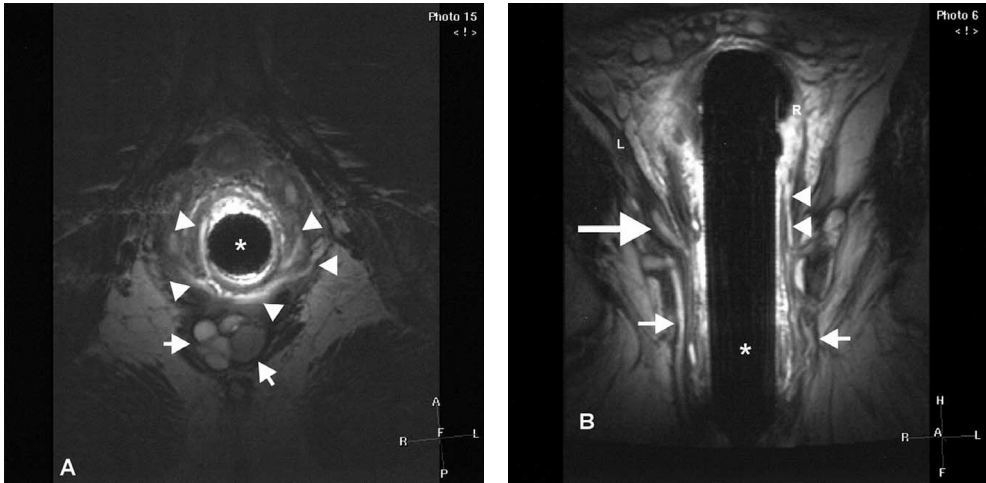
Horseshoe-type fistula with fluid collection. (A) Axial T2-weighted fast spin-echo (FSE) endoanal image (TR/TE = 2500/100 ms). Multiple circumferential spread of fistula tracks within the sphincter complex (arrowheads) with a fluid collection in the ischioanal space posteriorly (arrows). Please note the multiloculated aspect of the fluid collection with slightly different signal intensity within, suggestive of a chronic abscess. Endoanal coil (*). (B) On the coronal T2-weighted FSE image (TR/TE = 2443/100 ms) fistula extensions are also seen cranially within the external sphincter and puborectalis muscles (small arrows) and in the levator ani muscle (L) on the right (thick arrow). On the left cranial extension of a fistula track is seen into the rectal wall (arrowheads). R, rectum; endoanal coil (*).
